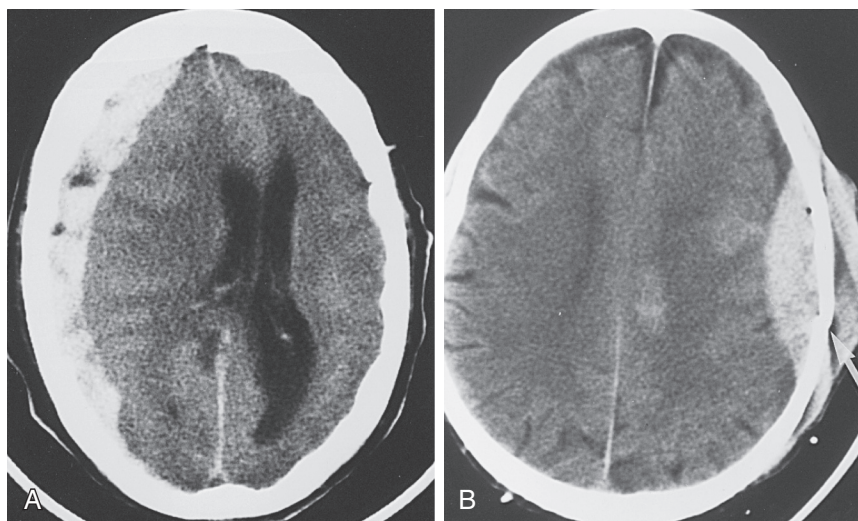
■ Subdural and epidural hematoma. A, Axial computed tomography (CT) scan of head demonstrates a mixed-density subdural hematoma along the right frontoparietal lobes. Mixed-density appearance is most likely due to presence of unretracted semiliquid clot. B, Axial CT scan of head demonstrates a left biconvex hyperdense collection that is classic for epidural hematoma. A fracture (arrow) can also be identified.
